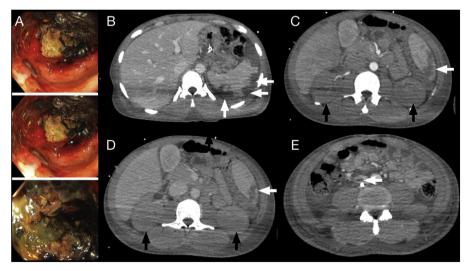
Twenty-three-year-old male migrant, with septic shock and acute renal failure. Colonoscopy also showed rectorrhagia and ischaemic colitis (A) and there were doubts around whether or not there was perforation. Therefore, a contrast-enhanced CT of the abdomen/pelvis was performed in the portal phase with images revealing no signs of perforation. They did however show: (B-D) Splenic infarcts. C and D) Overall low levels of enhancement of both kidneys both in the arterial and portal phases, suggestive of renal ischaemia (black arrows). (E) Contrast-enhanced CT of the abdomen/pelvis in the portal phase shows a central venous catheter in the inferior vena cava with adherent thrombus (white arrow).
